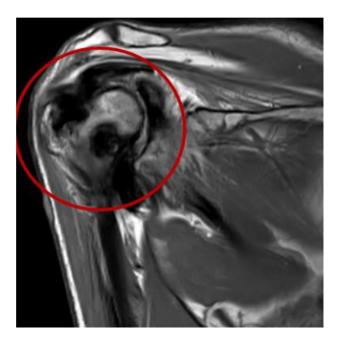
MRI of right shoulder joint T1 sequence shows erosive destruction of the right humeral head with loss of contour, articular cartilage, and erosions of the visualized part including greater and lesser tuberosity and glenoid margins (red circle).
